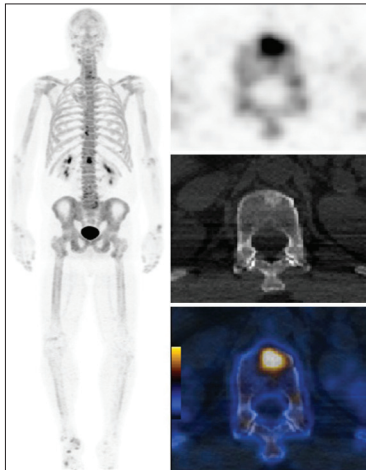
NaF-18-PET/CT images showing increased sclerotic activity within the anterior L1 vertebral body
